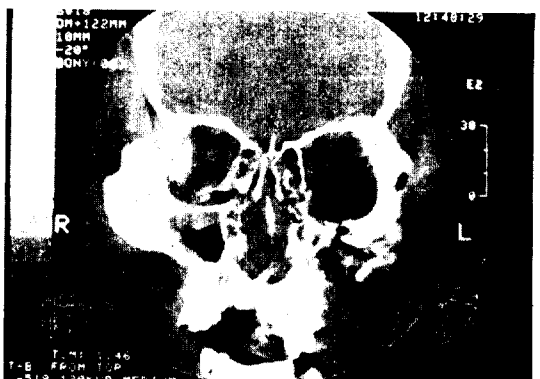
Preoperative CT showing pan-facial bone fracture with defect of left antral wall.
